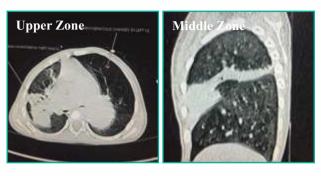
CT Lung: Emphysematous changes in the left lung, atelectasis seen in the anterior segment of the upper lobe and middle lobe of right lung and anterior segment of lower lobe of the left lung. Pulmonary oligemia seen involving the upper lobe of left lung, mild mosaic attenuation seen in right lung field.
